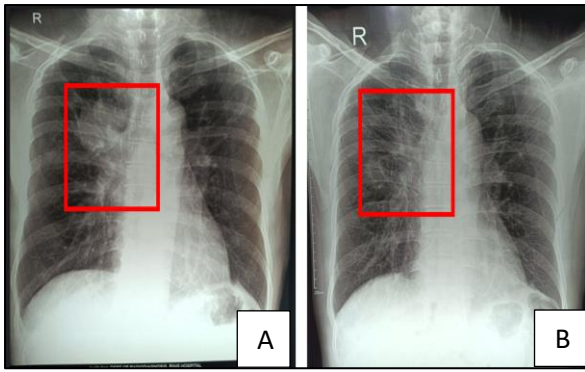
Anteroposterior X-Ray film of the chest wall showing partial response after the treatment (A) Pre-treatment (B) 6 weeks after completion of the treatment.
